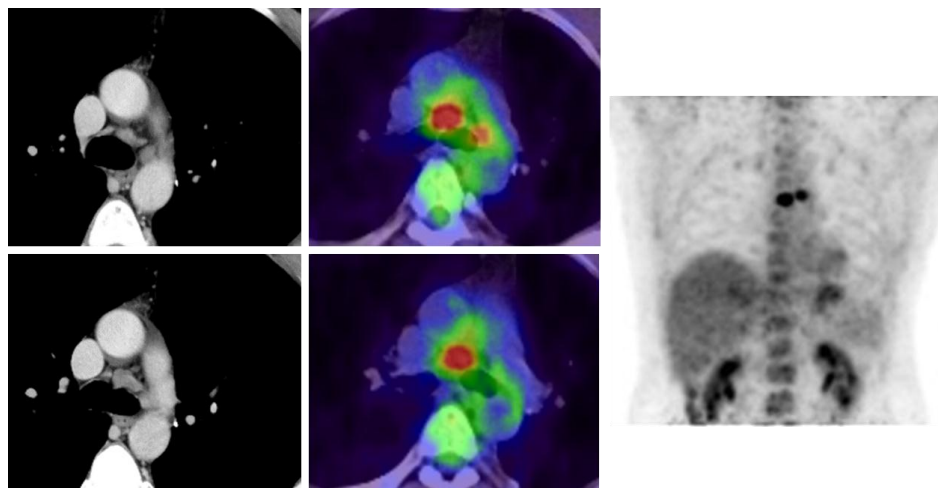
The CT and the PET showed the paratracheal lymph node metastasis 17 months after starting crizotinib therapy.
